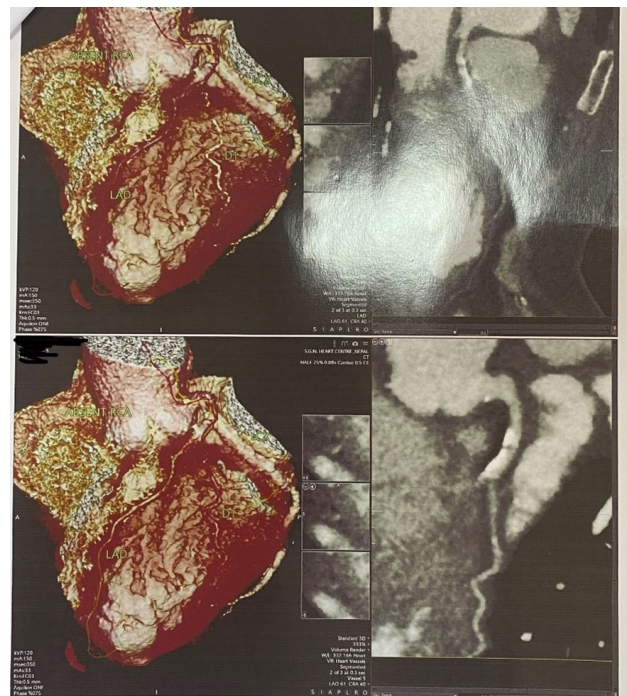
Coronary CT Angiography showing absent RCA and RCA territory being supplied by a branch from LCX.
